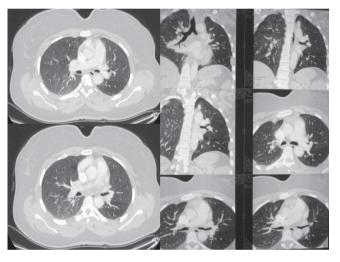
Postoperative 3 months CT imaging.
